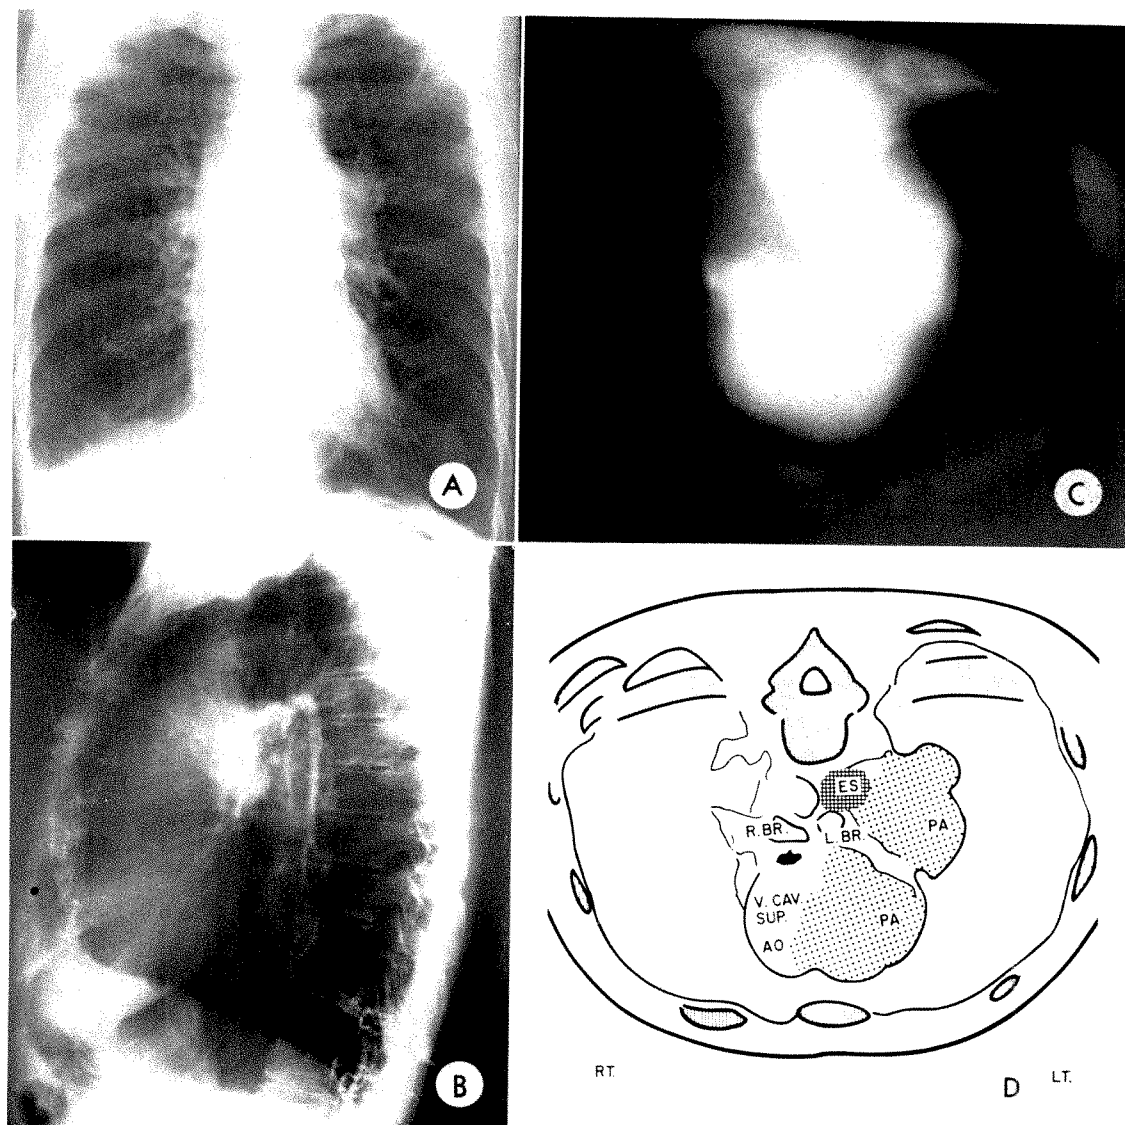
Case 11. In this sixty-five year old man with a carcinoma of the mid-esophagus, the conventional roentgenogram (A) of the chest shows a prominent left hilar mass suggestive of tumor or a prominent left pulmonary artery.
